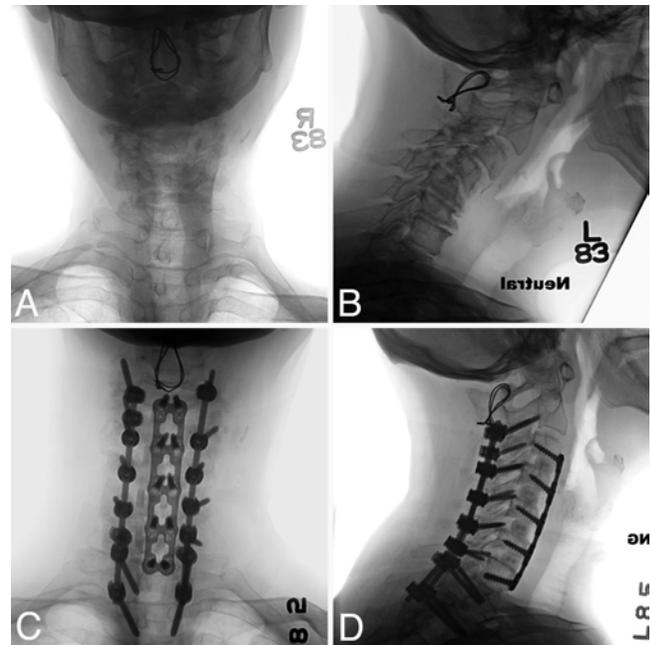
Case 25. This 72-year-old woman with a 50-year history of rheumatoid arthritis had undergone posterior C1–2 fusion in 1987 and since then had had trouble with progressive ataxia, neck pain, and hand dexterity. Preoperative anteroposterior and lateral (A and B) radiographs demonstrated C2–3, C3–4, and C4–5 anterolisthesis and severe degenerative disc disease. She underwent same-day combined anterior-posterior surgery with C3–4, C4–5, C5–6, C6–7 anterior discectomies, and C3–7 anterior instrumentation and fusion with plating followed by C2–T2 posterior instrumented fusion (C and D). The changes in occiput–C2 and C2–7 angles were -6° and 27° , respectively. Postoperatively the patient developed dysphagia and required an NG tube and subsequent PEG tube placement. The dysphagia resolved within 3.5 months following surgery.
